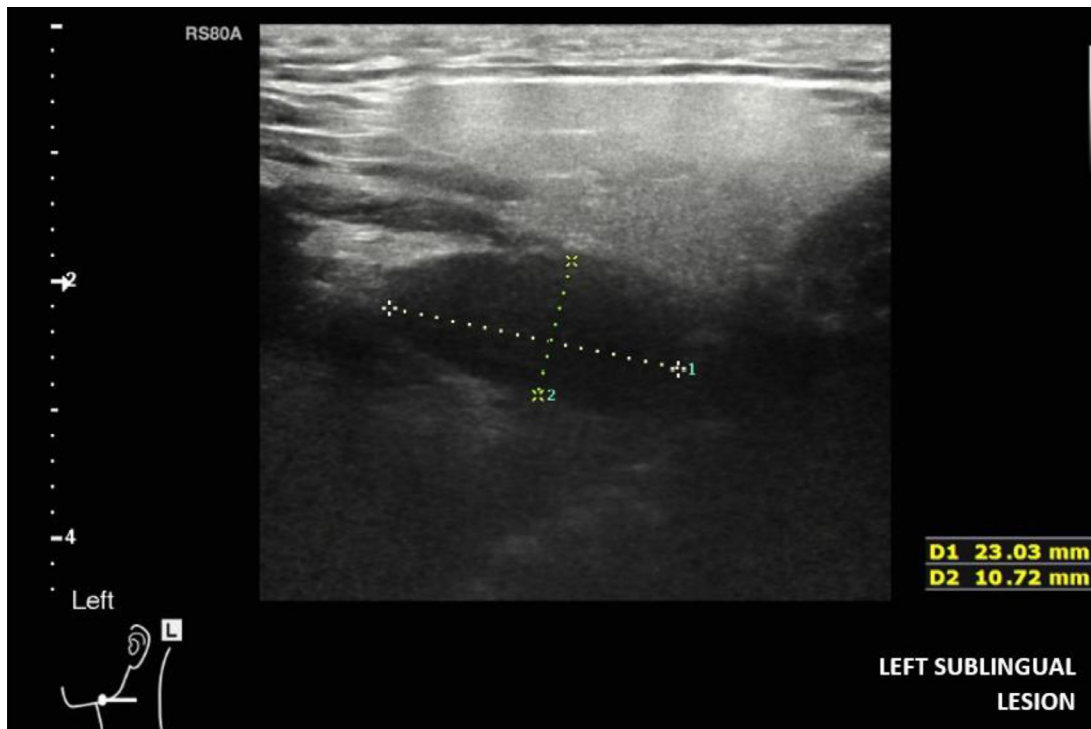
Ultrasound: transverse view of the left submandibular region showing a well-defined hypoechoic area deep to the submandibular gland, suggestive of tongue lesion.
